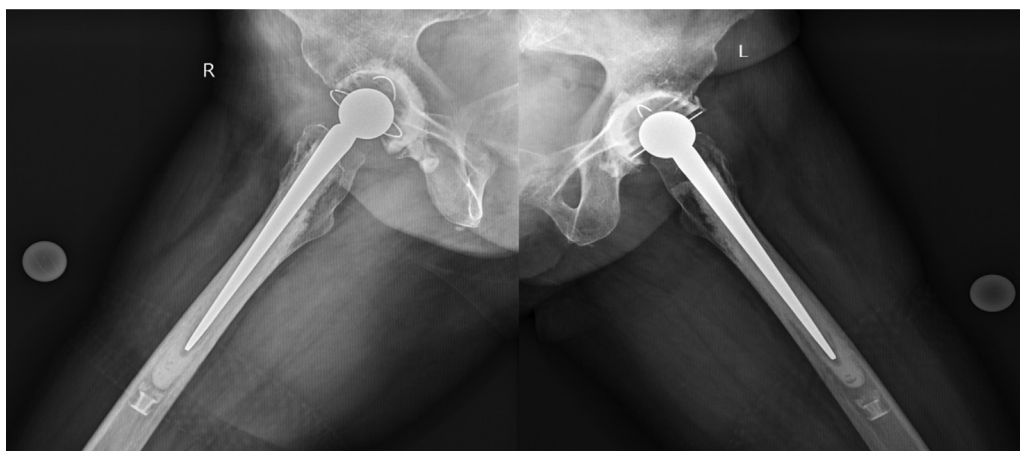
Postoperative lateral radiograph after bilateral cemented arthroplasty.
